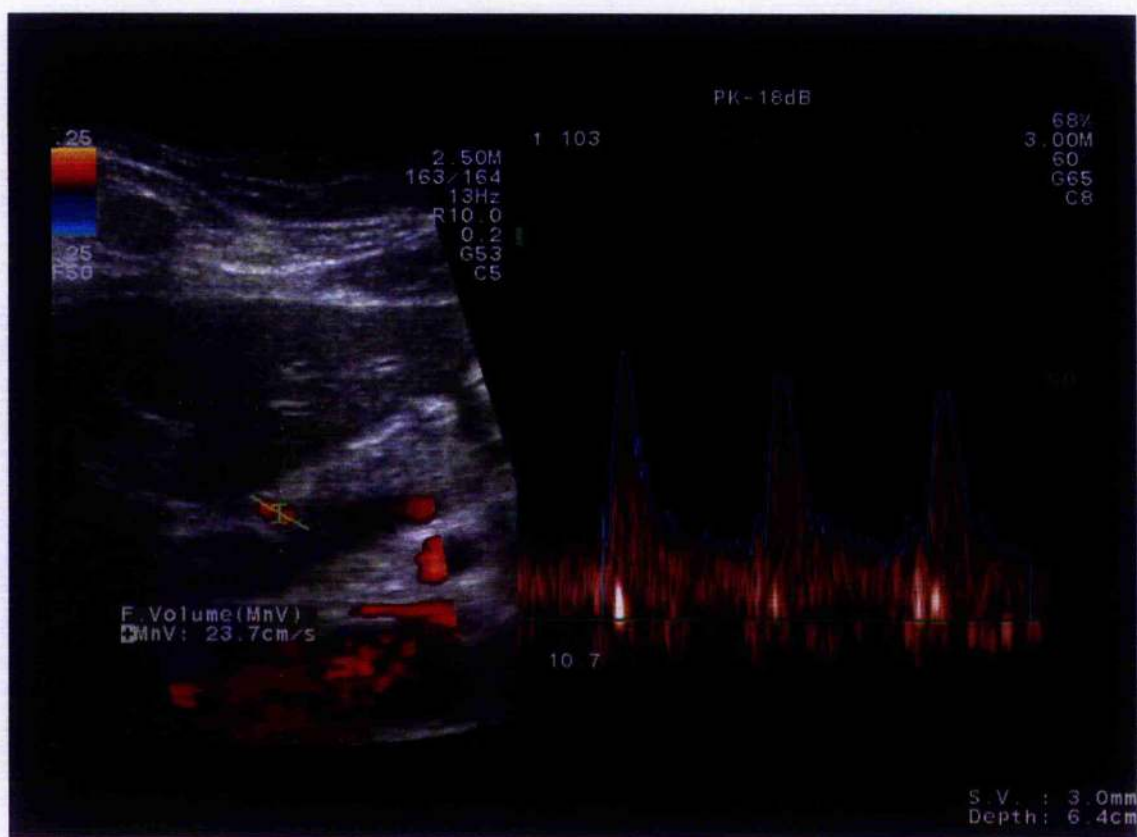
Figure C Colour Doppler ultrasound image and corresponding Doppler trace of hepatic artery. Example of time average mean velocity shown (F. Volume MnV : 23.7cm/s).
